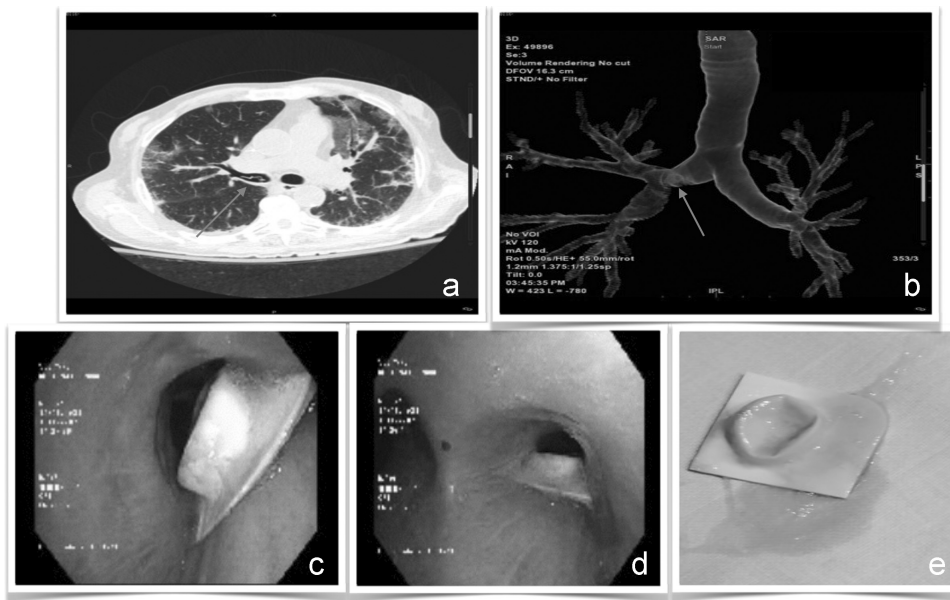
Image a. Visualization of the foreign body in thoracic CT (indicated by the arrow). Image b. Reconstruction of the bronchial tree with foreign body at the level of the right main bronchus (indicated by the arrow). Image c. Impacted foreign body in the right main bronchus with image from the main carina. Image d. Visualization of foreign body impacted at the entrance of the right main bronchus. Image e. Foreign body once removed by biopsy forceps.
